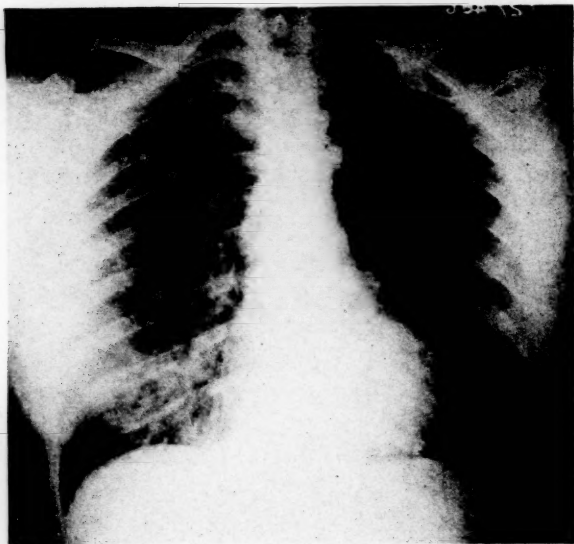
Case 1, x-ray taken on July 27th, five days later. A remarkable degree of clearing has taken place.
